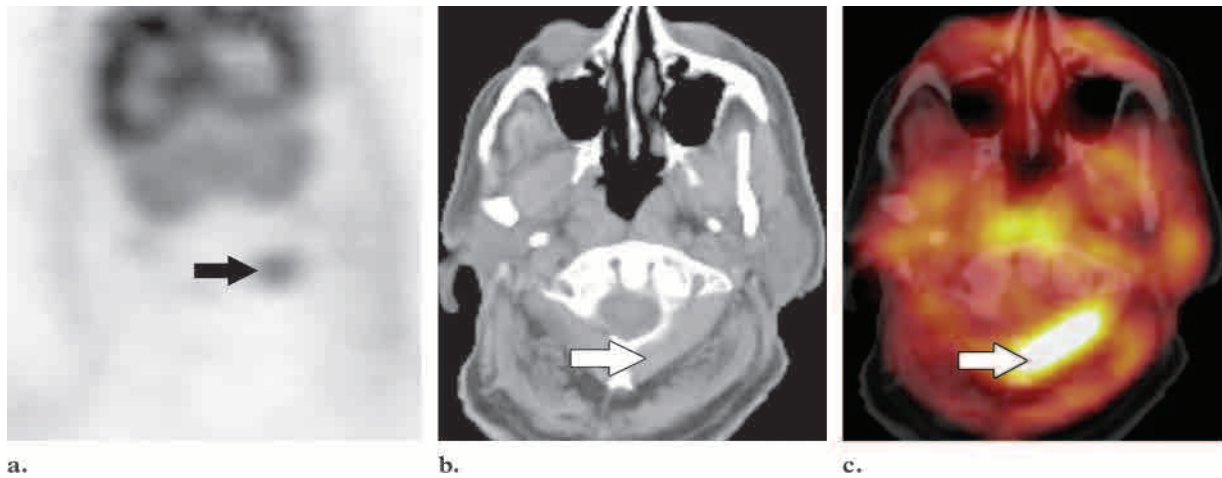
Asymmetric uptake in the inferior obliquus capitus muscle. (a) Coronal PET scan shows a hypermetabolic focus in the left side of the neck (arrow). (b) Axial CT scan reveals no correlative abnormality. Arrow indicates the left inferior obliquus capitus muscle. (c) Axial fused PET-CT scan helps confirm prominent asymmetric physiologic FDG uptake in the left inferior obliquus capitus muscle (arrow).
